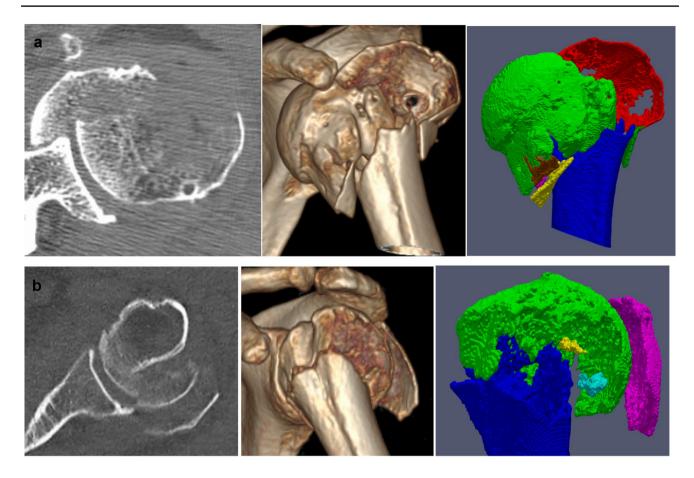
a Head split proximal humeral fracture (case number 8 in Table 1). b Three-part proximal humeral fracture (case number 13 in Table 1). Respectively from left to right: a standard spiral CT scan
